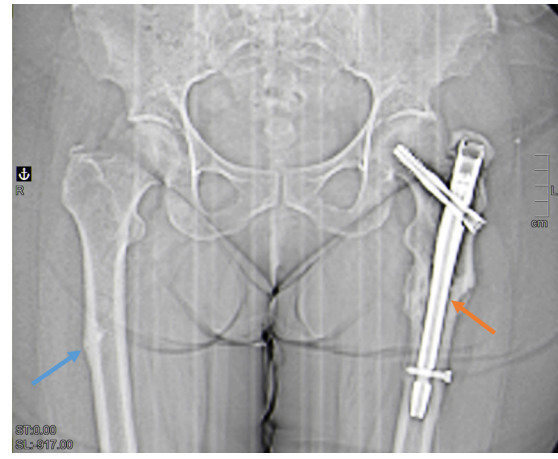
Scout image from another follow-up abdominopelvic CT, acquired 15 months before the second fracture shown in fig. 3, shows an intramedullary nail (orange arrow) from previous fixation of a left femoral fracture, with fracture callus in the subtrochanteric region. In the right femur, lateral cortical thickening is observed (blue arrow), representing a prodromal radiological sign of a bisphosphonate-related atypical femoral fracture.
